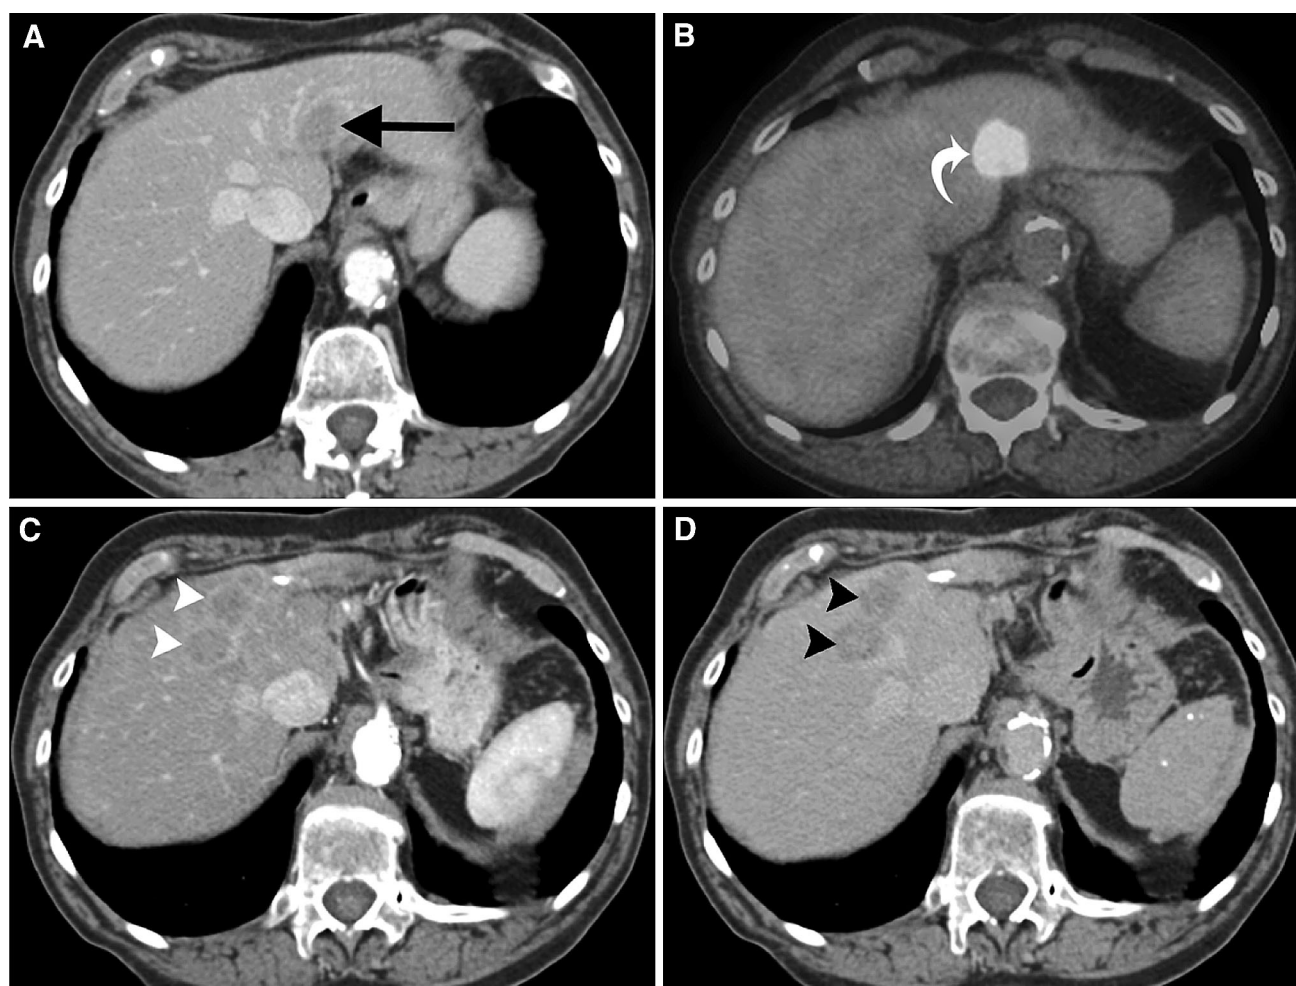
CHC in an 83-year-old noncirrhotic woman. A, B Axial-enhanced CT and fused PET/CT demonstrate a rim-enhancing, centrally hypoattenuating (*black arrow*), hypermetabolic mass (*curved white arrow*) in the left hemiliver. C, D
